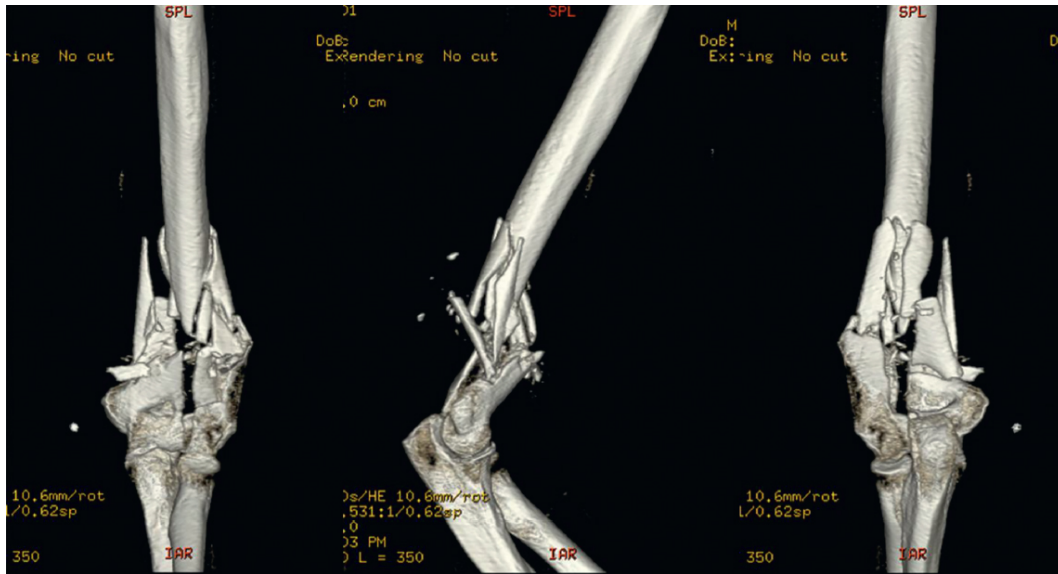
CT with 3D reformatting.
